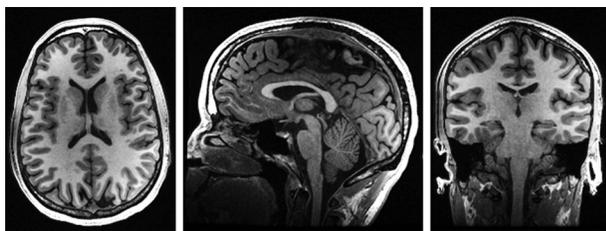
Magnetic resonance image of a healthy 25-year-old female brain. Axial view (left), sagittal view (middle), and coronal view (right).
